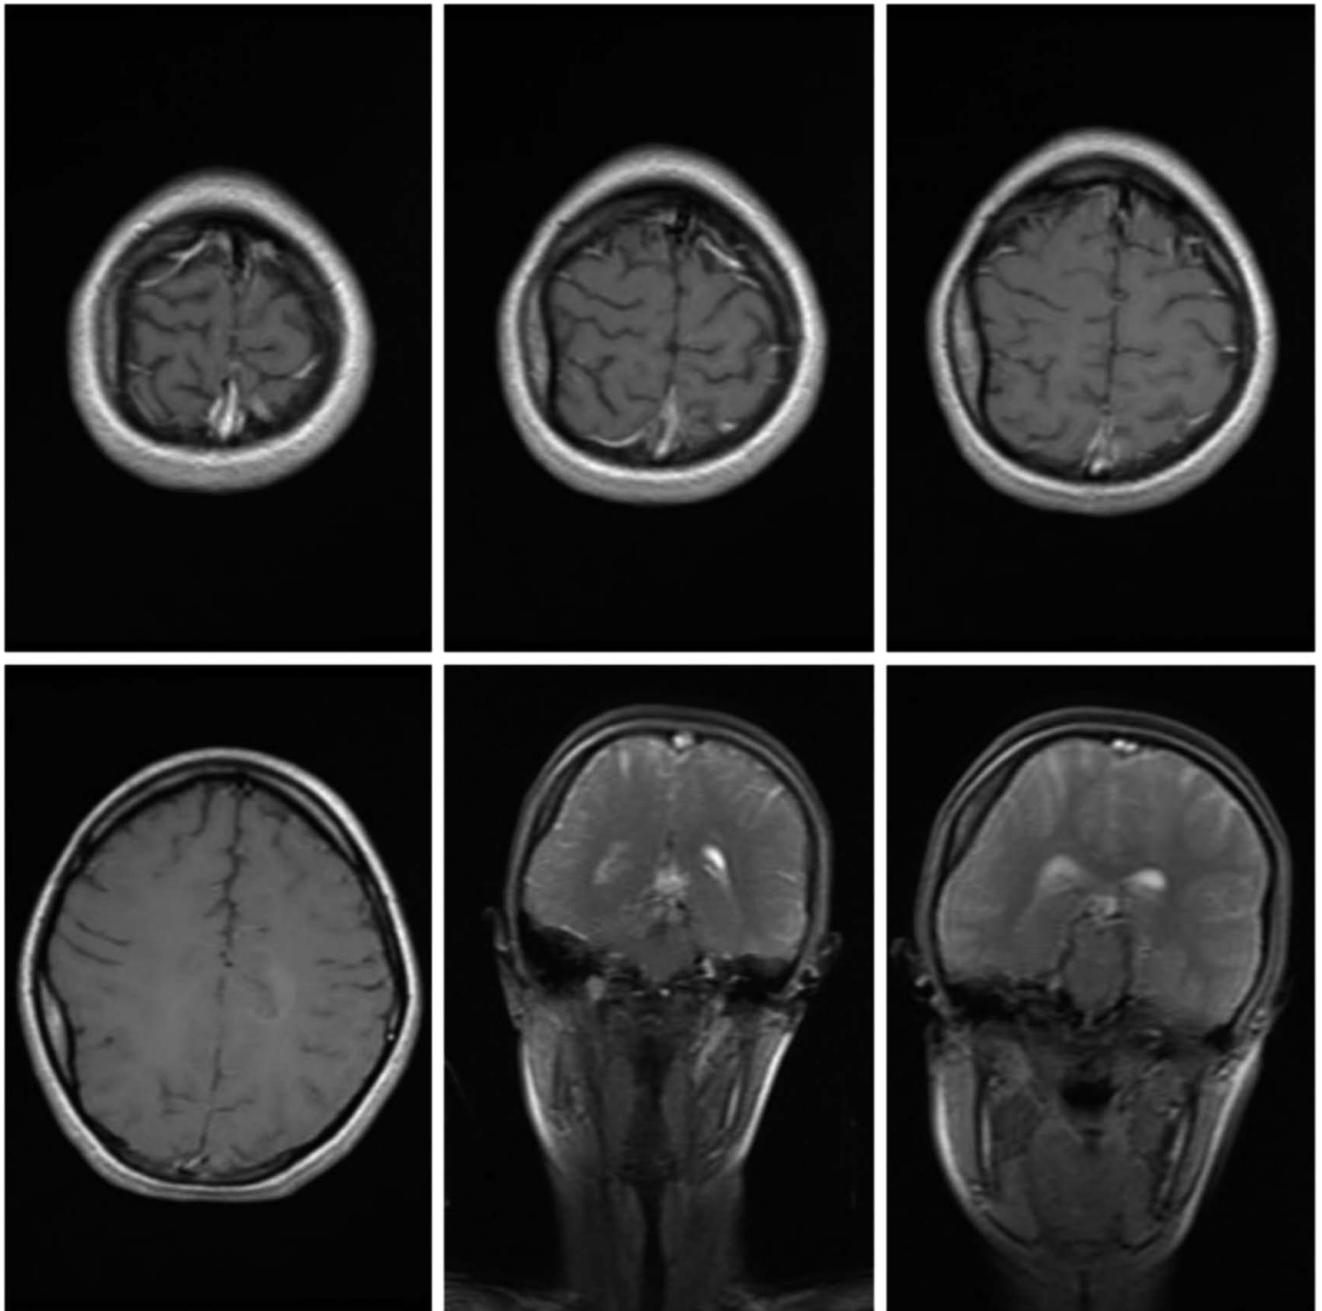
MRI with contrast shows an abnormal signal hyperintensity area is noted in the left top parietal region with no significant post contrast enhancement suggestive of contusion/hemorrhage in the left parietal lobe.
